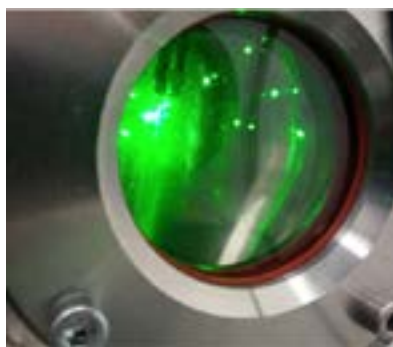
Phase Doppler interferometry for the on-line metrology
